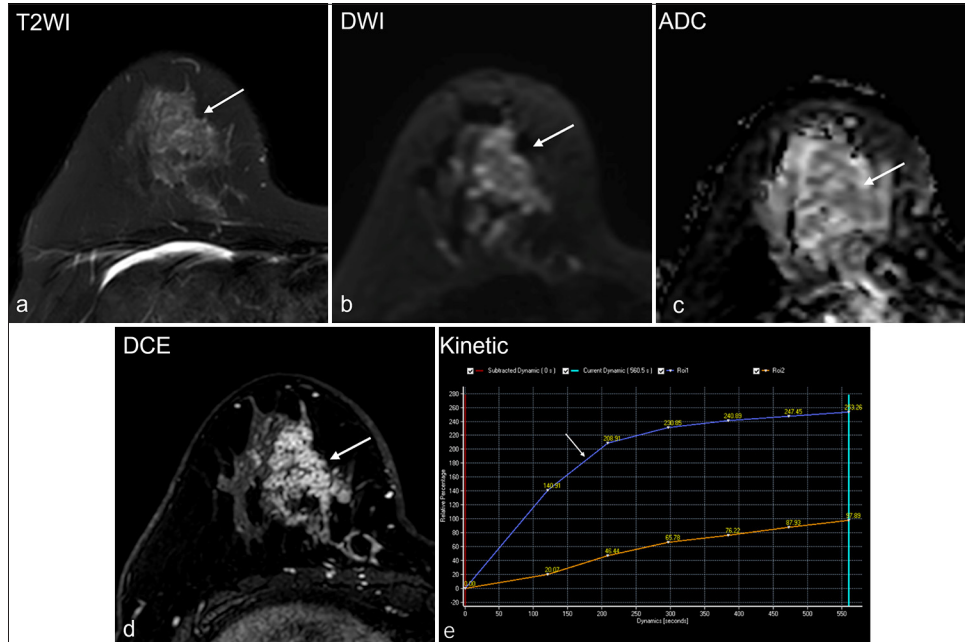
A 40-year-old woman diagnosed with invasive ductal carcinoma of the human epidermal growth factor receptor-2 subtype. (a) The lesion presents isointense on T2-weighted imaging (white arrow), (b) uneven high signal on diffusion-weighted imaging (white arrow), (c) corresponding low signal on apparent diffusion coefficient (ADC) mapping (white arrow), the average ADC value is $1.31 \times 10^{-3} \text{mm}^2/\text{s}$. (d) The initial phase of dynamic contrast enhancement shows a segmental clustered ring enhancement (white arrow), (e) the kinetic curve (white arrow) demonstrates a persistent appearance (type I curve). (T2WI: T2-weighted imaging, DWI: Diffusion-weighted imaging, DCE: Dynamic contrast enhancement)
